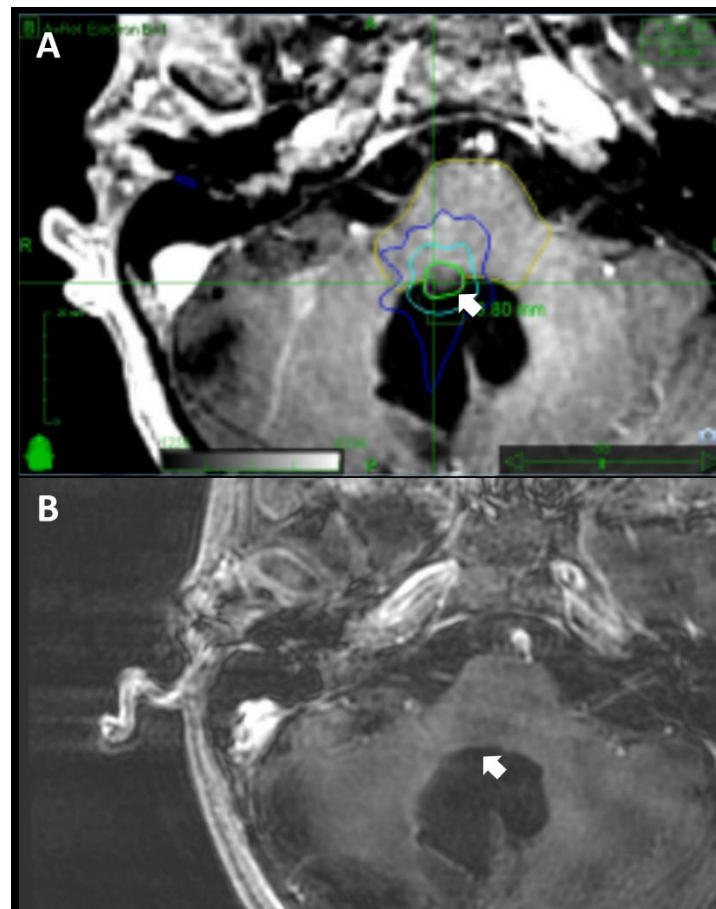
Comparison of A. a baseline CyberKnife treatment plan and B. the most recent radiographic follow-up evaluation of a 11-year-old male patient with a cervicomedullary recurrent medulloblastoma status post surgical resection and adjuvant radiation therapy. A marginal dose of 18 Gy was delivered with the maximum dose of 24.16 Gy in a single fraction to 75% of the isodose line (A). A substantial reduction in tumor size was evident in the 41-month follow-up MRI (B).
